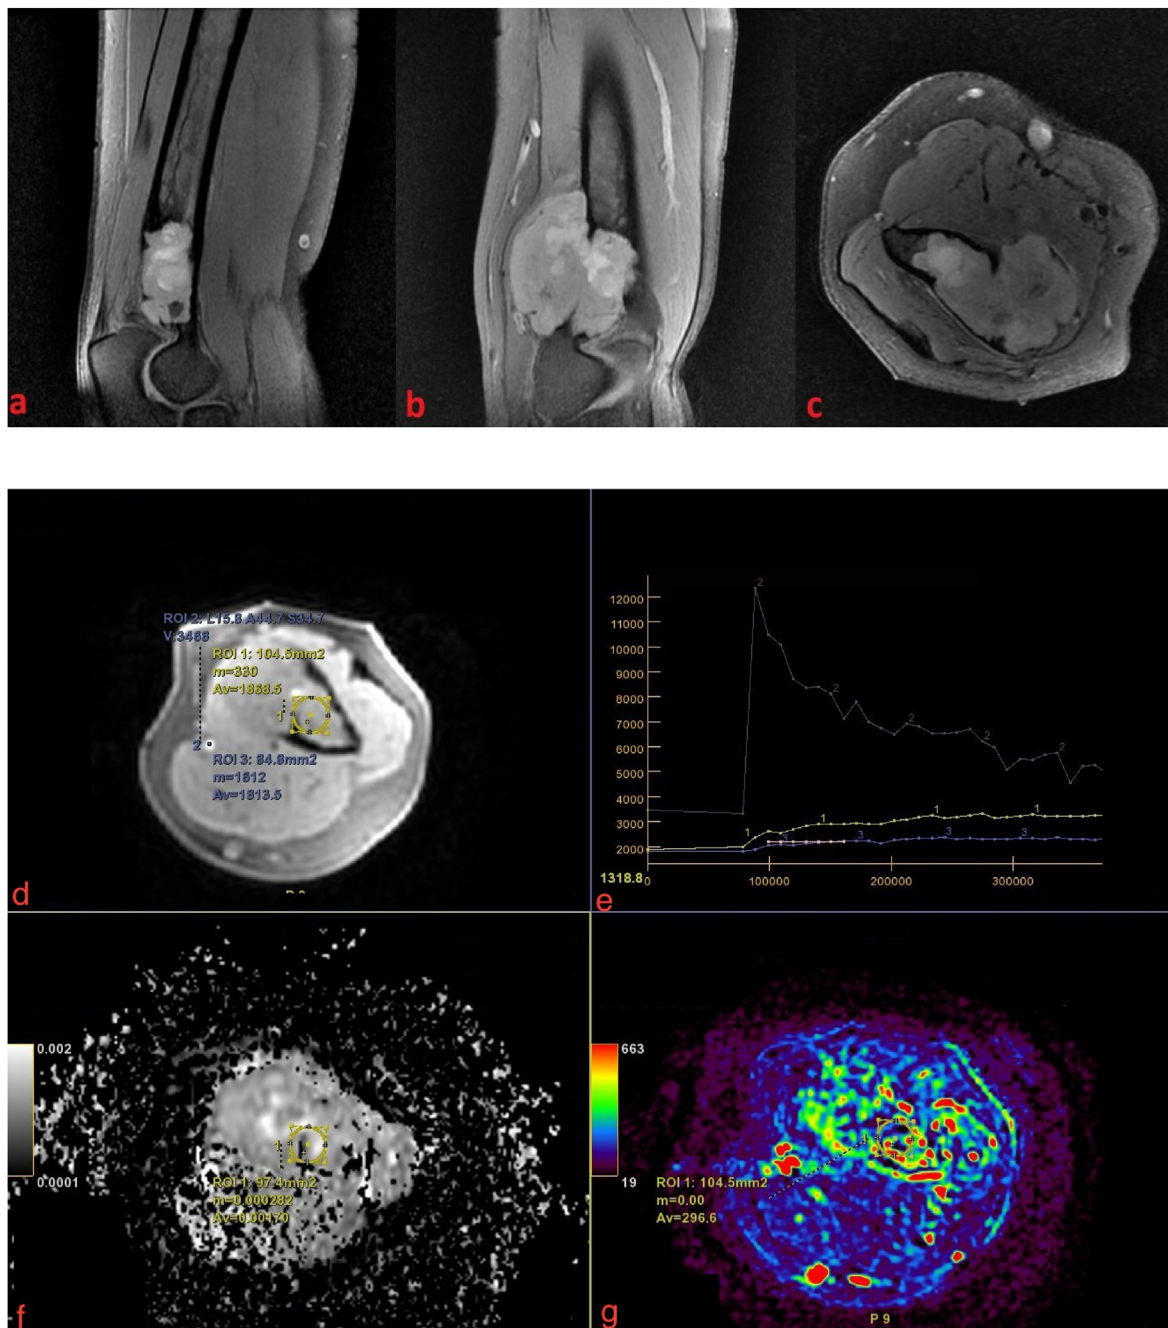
Conventional MRI images of a 22-year-old male patient presenting with pain in elbow. Sagittal T2 image (a) and coronal proton density fat suppressed (PDFS) (b) showing a hyperintense expansile lesion in distal metaphysis of humerus. Axial PDFS (c) image showing cortical thinning at the lateral margin of the lesion.
